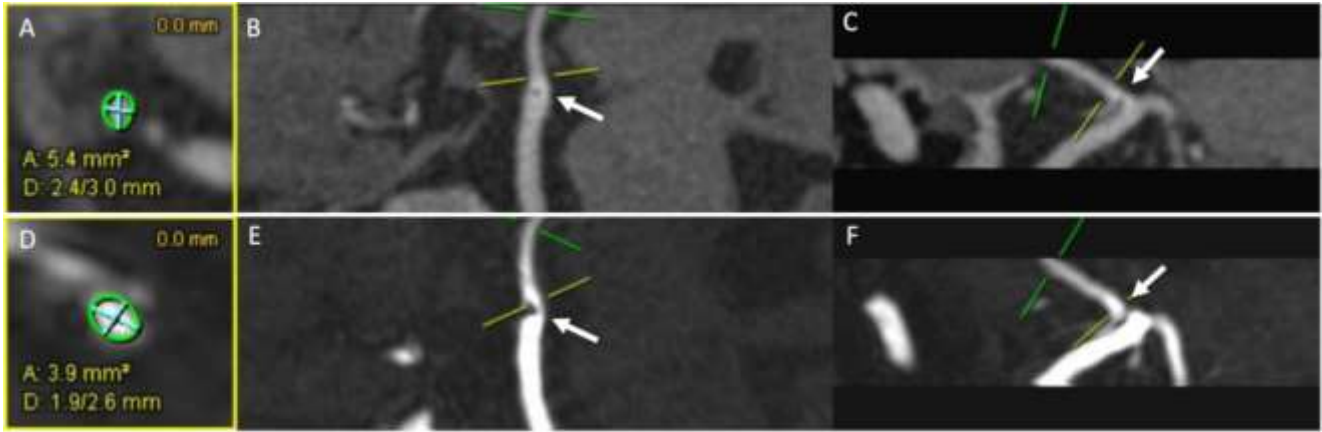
Representative case of the virtual stenosis analysis: The minimal diameter is calculated as transverse vessel surface in mm² (A, B, C: UTE MRI, D, E, F: TOF MRA). Note the smaller cross-sectional surface vessel in TOF MRA (D-F) caused by the greater artefact of the WEB-detachment zone (arrows) compared to UTE MRI (A-C).
